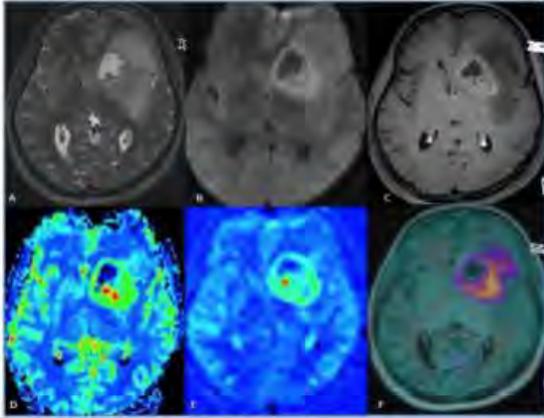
Case of anaplastic astrocytoma. Axial T2W (A) images shows a heterogeneous mass lesion in the left frontal lobe and insular region. DWI (B) shows diffusion restriction along the periphery and posterior aspect of the lesion. Axial T1 W post contrast image (C) shows peripheral and nodular areas of enhancement. DSC perfusion (D) and 3D PCASL image (E) shows increased perfusion in these enhancing areas. C11 methionine PET image (F) shows tracer uptake along the periphery and posterior part of the lesion
